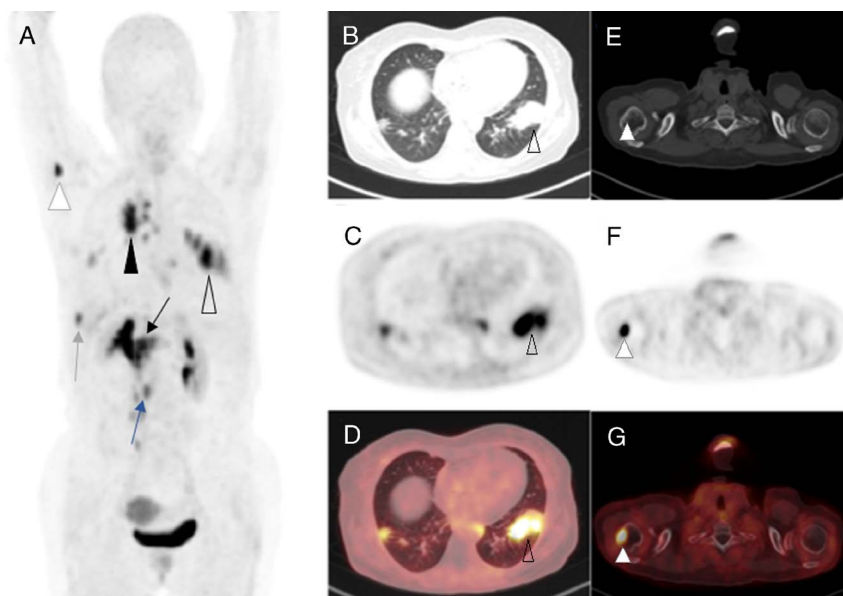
Because of progressive disease and no other available approved treatment, the patient underwent ^{68}Ga -FAPI-46 PET/CT scan within 2 weeks of the ^{18}F -FDG PET/CT scan to evaluate for a possible ^{177}Lu -FAPI-46 therapy. The MIP image of ^{68}Ga -FAPI-46 PET (A) showing local recurrence (black arrow) and metastatic disease in the right humerus (white arrowhead), lungs (blank arrowhead), mediastinal (black arrowhead) and retroperitoneal (blue arrow) lymph nodes, and liver (gray arrow). Axial view images showing pulmonary metastasis (B, CT; C, PET; D, fused PET/CT) and metastasis to the right humerus (E, CT; F, PET; G, fused PET/CT).
